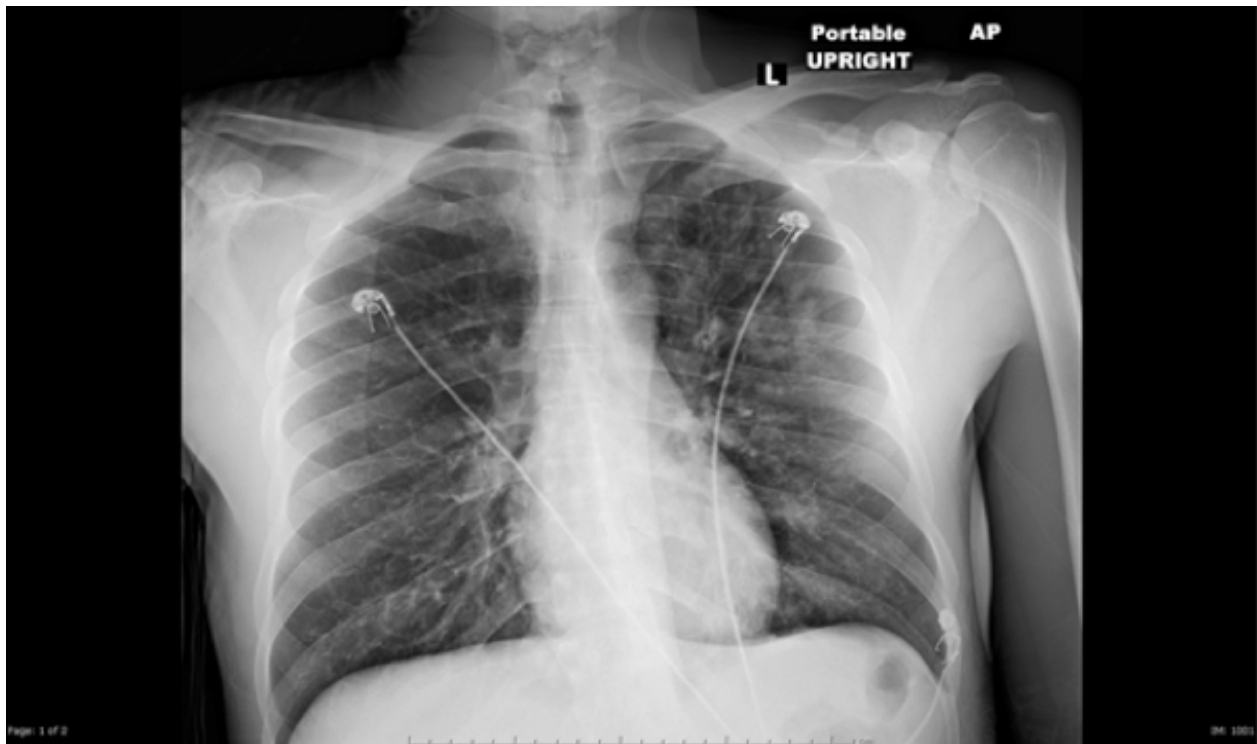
Chest radiograph of patient at presentation with respiratory distress.
